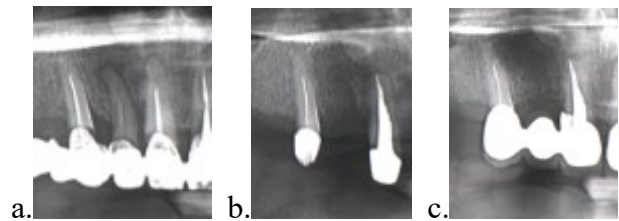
OPT X-ray performed five weeks after initiation of pulsed short wave therapy. Intense remineralization of alveolar bone structures around the teeth and interdental bone septa can be observed.
